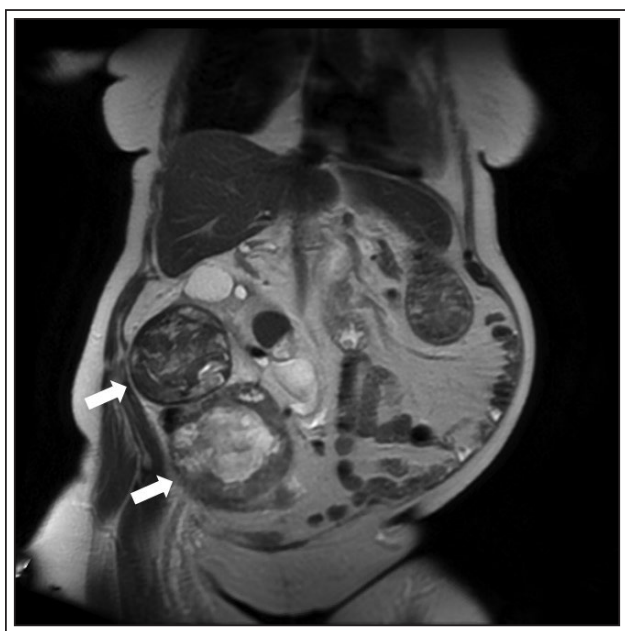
Coronal MRI demonstrating two large renal masses of mixed signal intensity in the right lower quadrant arising from the transplant kidney (upper mass 7.7 cm x 8.2 cm; lower mass 10.8 cm x 10.9 cm).
